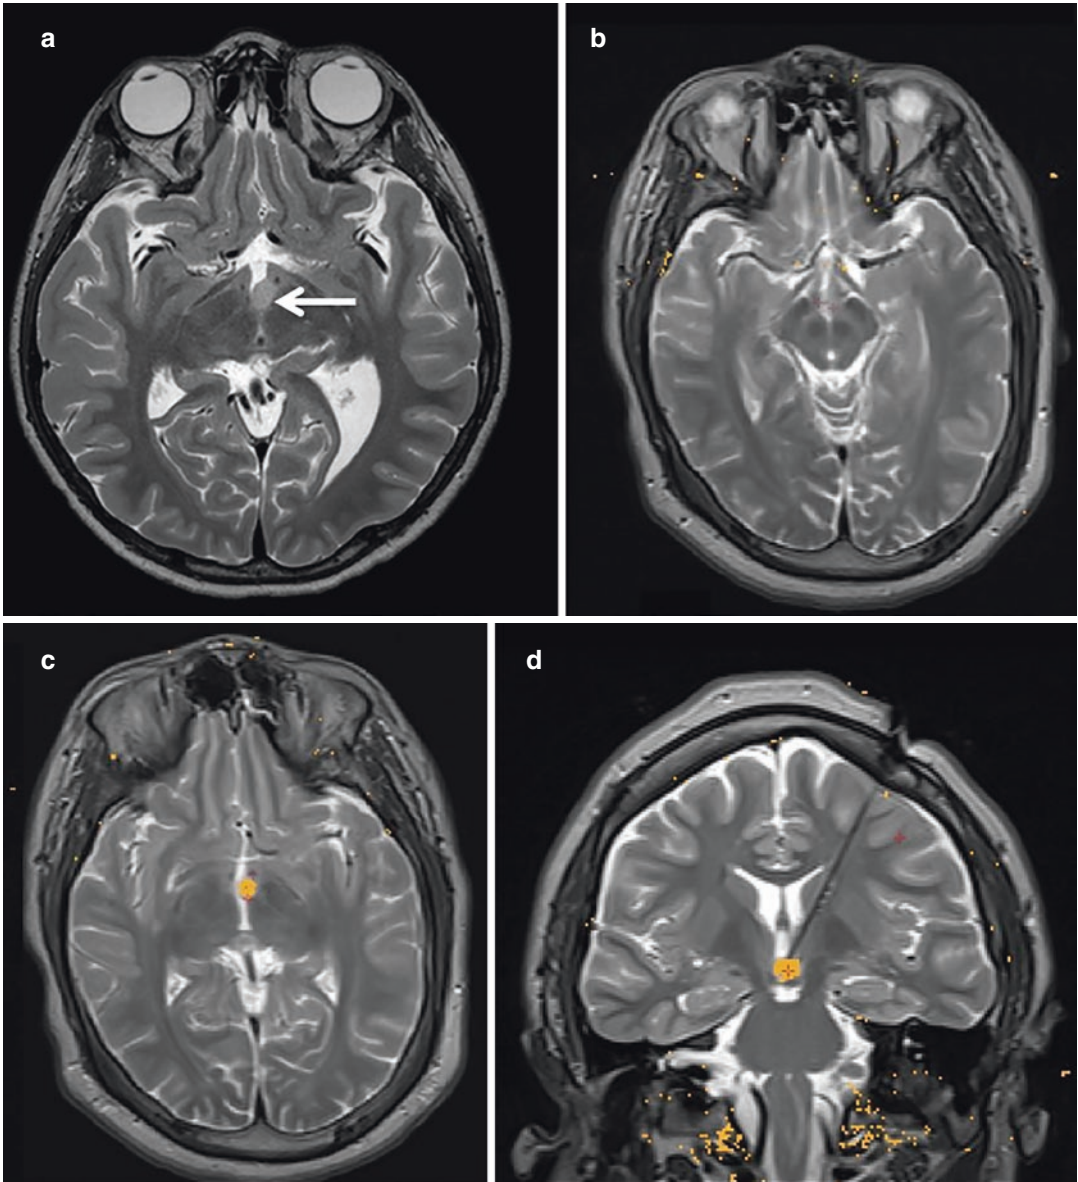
MRgLITT for hypothalamic hamartoma. (a) Axial T2 MRI showing a left Delalande Type II hypothalamic hamartoma (*arrow*). (b) Axial T2 MRI of the most inferior slice of the lesion showing the catheter in place and low-limit markers on the left and right mammillary bodies. (c) Axial T2 MRI of a superior half of the lesion showing a TDE covering the hamartoma and low-limit markers protecting the left fornix and the left mammillothalamic tract. (d) Coronal T2 MRI showing the catheter
